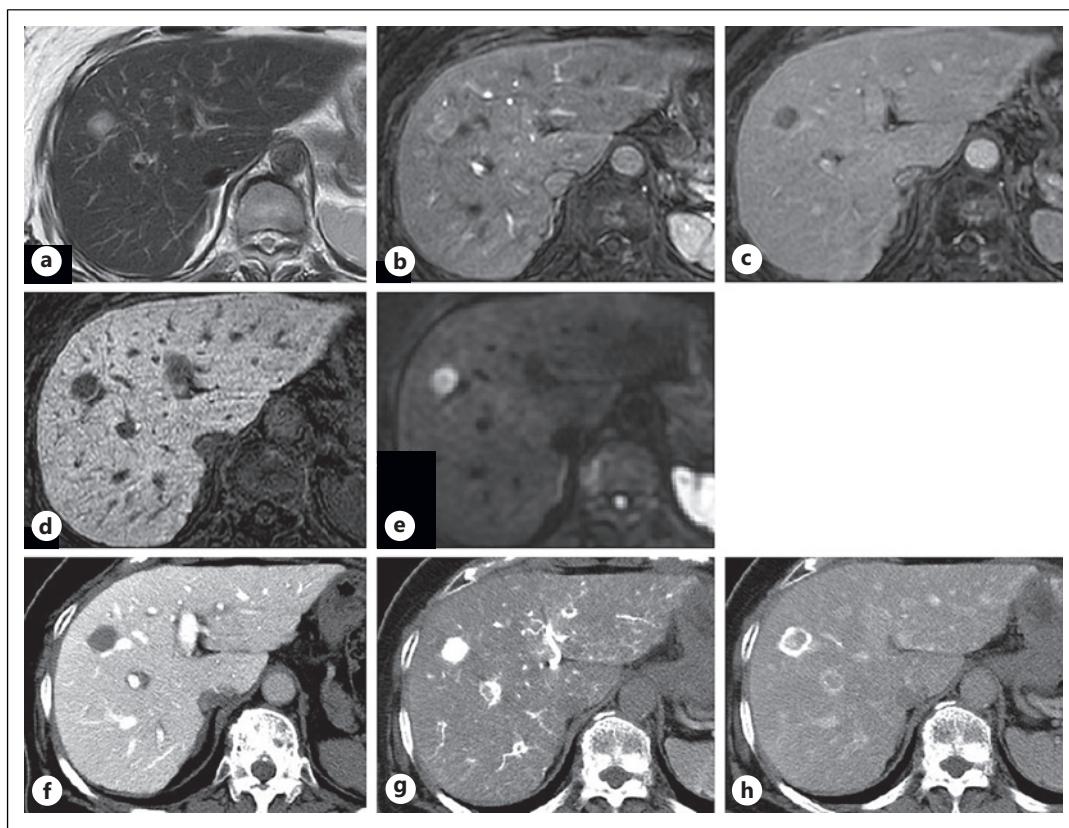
Imaging liver tumors before RFA. T2-weighted (a), arterial phase (b), portal phase (c), hepatocellular phase (d), and diffusion-weighted image (e) of Gd-EOB-DTPA-MRI; CT during arterial portography (CTAP) (f), CT during hepatic arteriography (CTHA) early phase (g), CTHA late phase (h).
